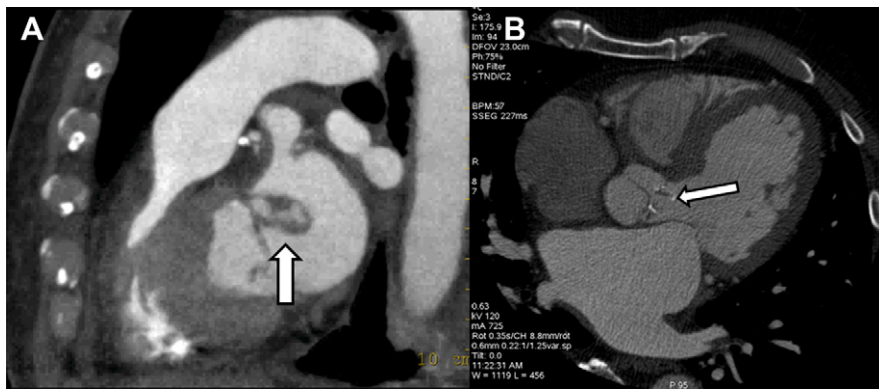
Multidetector computed tomography angiography shows various examples of endocarditis. (A) Oblique two-chamber view shows a vegetation attached to the anterior mitral valve leaflet (arrow). (B) Five-chamber view shows small vegetations attached to the aortic valve (arrow).
